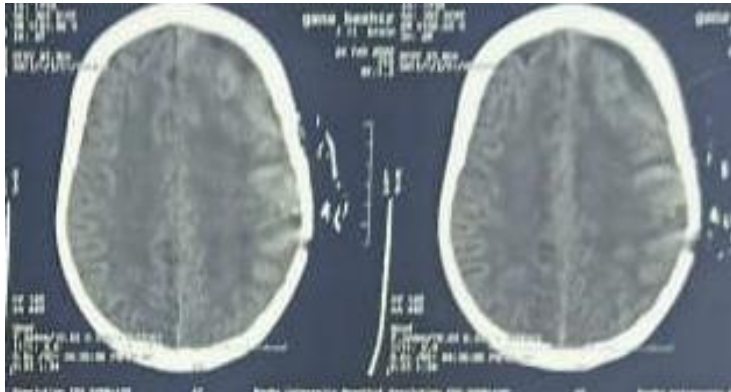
Postoperative CT brain, axial views show evacuation of the collection through left temporal burr hole.
